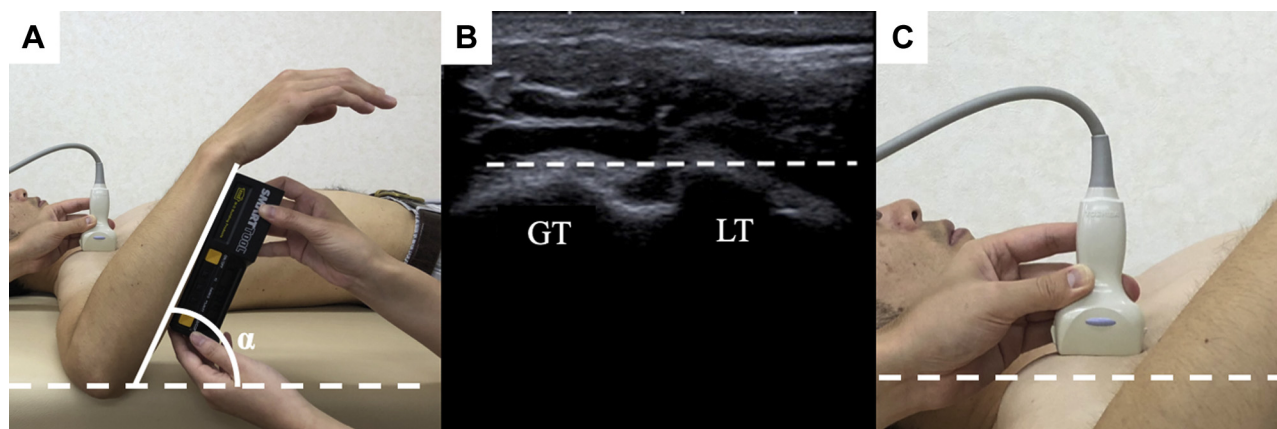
The humeral torsion angle was measured using ultrasonography, as previously described.^{15,18} Players were placed in the supine position with the shoulder at 90° of abduction, the elbow at 90° flexion, and the forearm in the neutral position. (A) The humeral torsion angle was defined as the angle (α) between the long axis of the forearm and a line parallel to the trunk, (B) when the line tangential to the greater tuberosity (GT) and lesser tuberosity (LT, forming the bicipital groove) was parallel to the horizontal baseline on the ultrasound monitor, (C) while the ultrasound probe was held parallel to the floor. The humeral torsion angle (α) was measured using a digital inclinometer (Smart Tool, M-D Building Products; accuracy, 0.1°) placed on the palmar side of the forearm.
